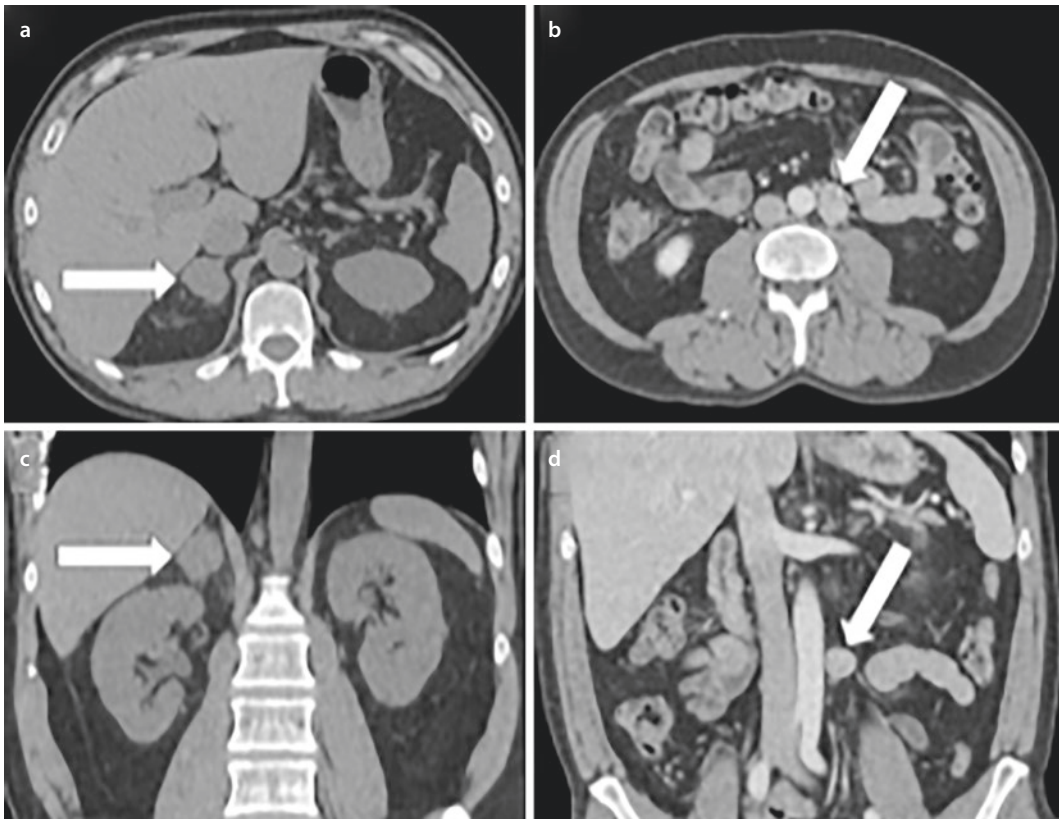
CT scan images from a 53-year-old man with right adrenal pheochromocytoma and multiple paragangliomas. Panels a and b unenhanced axial (above) and coronal (below) images show a lipid poor (35 Hounsfield units) 2.4×3.1 cm right adrenal mass (arrows). With contrast administration the absolute and relative contrast washout values at 15 minutes were 50% and 27%, respectively. Panels c and d contrast-enhanced axial (above) and coronal (below) images show a 2.0×2.8 cm left para-aortic retroperitoneal mass (arrows)
